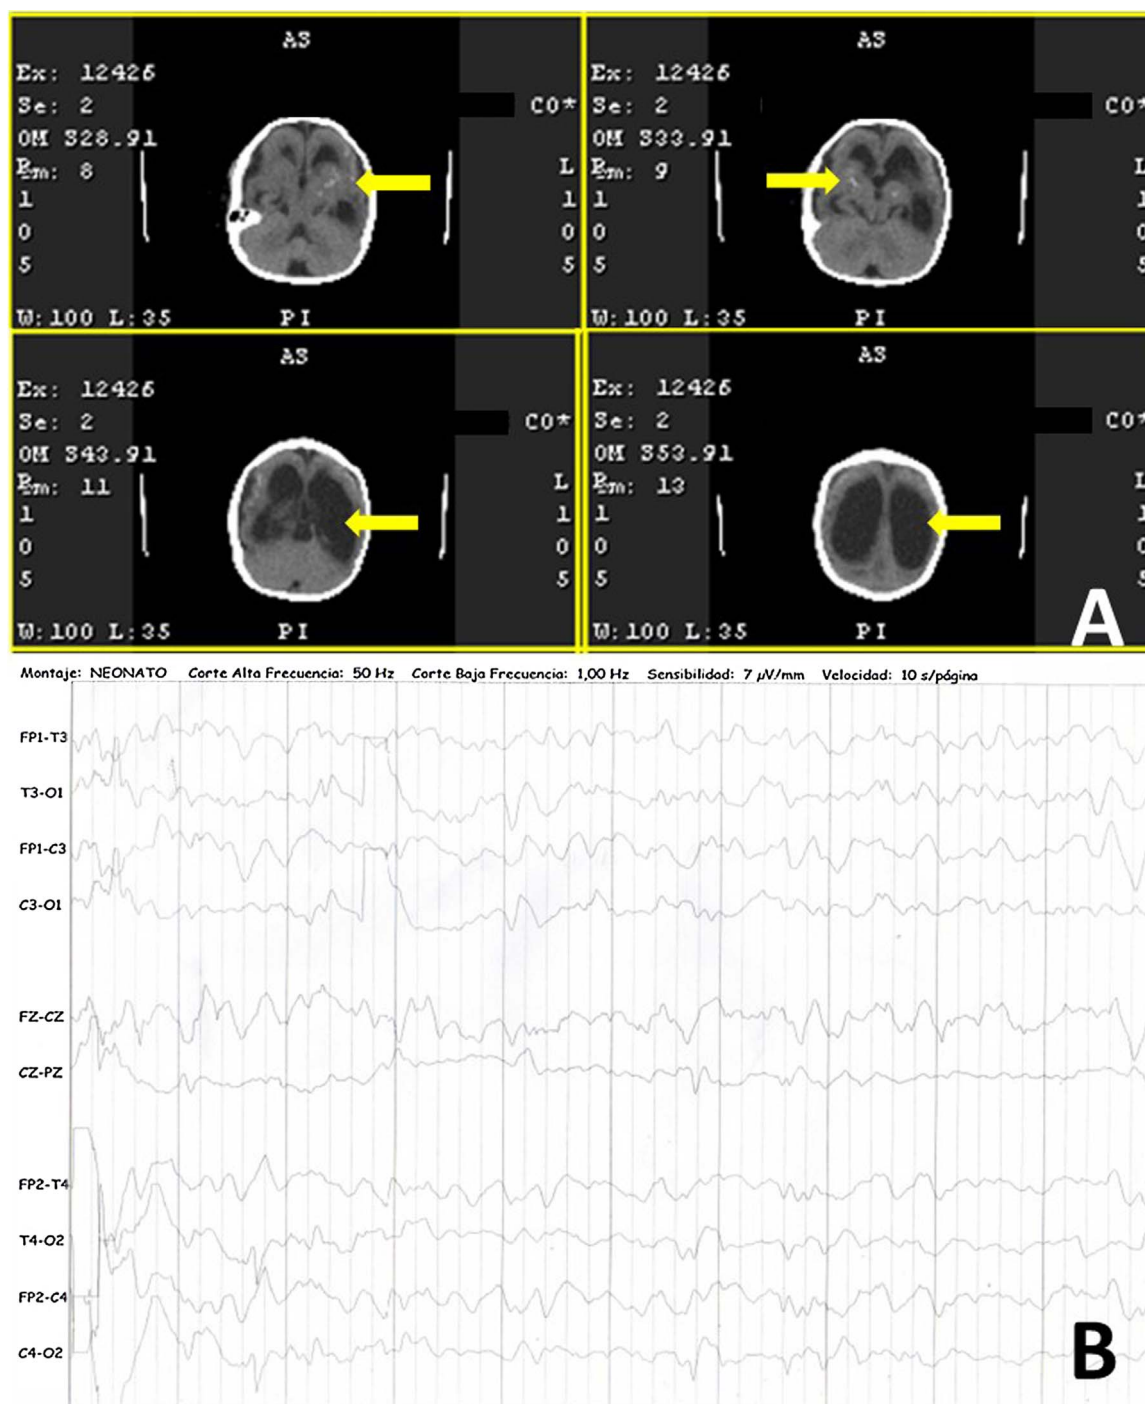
A Findings at CT-scan, including microcephaly, ventriculomegaly, basal ganglia and bilateral subcortical calcifications. B. EEG, slightly altered, with inadequate modulation.
